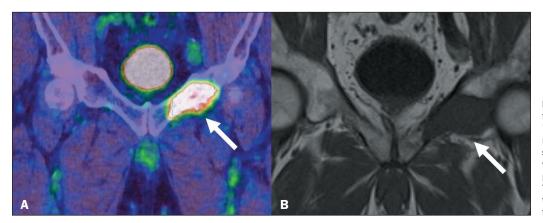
⁶⁸Ga-PSMA PET/CT for prostate cancer staging in a 78-year-old male patient. Abnormal PSMA uptake (SUVmax, 10.4), suggestive of bone metastasis, was identified in the left ischiopubic ramus (arrow in A). Coronal T1-weighted MRI scan (B) showing the corresponding imaging feature (arrow).
